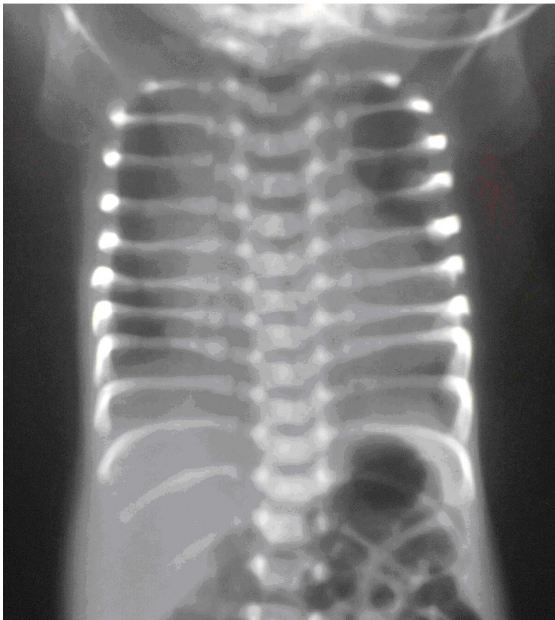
chest xray showing long narrow thorax and short and horizontally oriented ribs with irregular costochondral junctions and bulbous and irregular anterior ends
